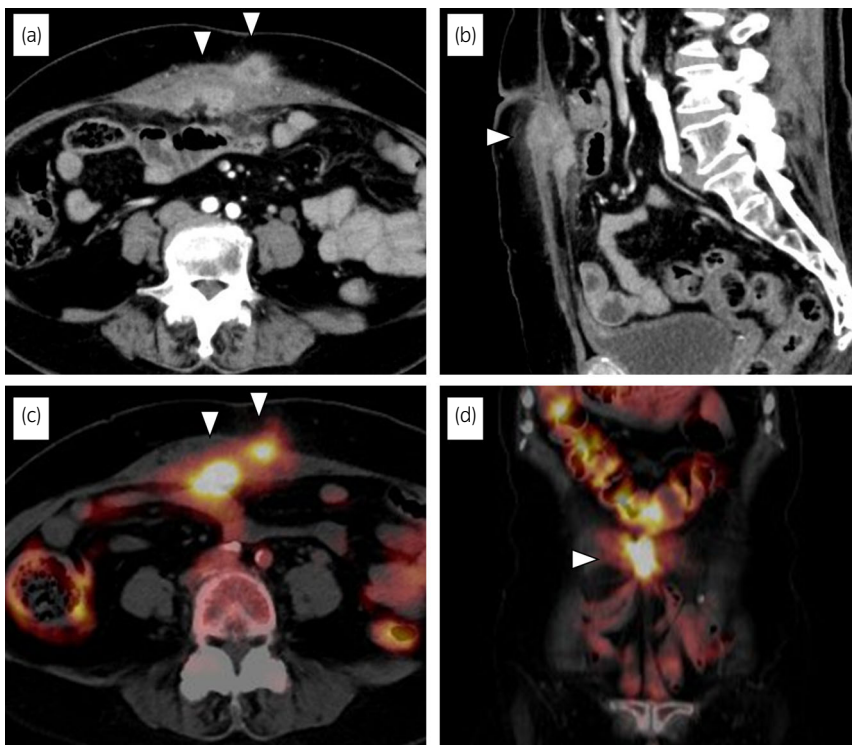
Computed tomography (CT) images of the abdominal wall mass suspected to be a urachal carcinoma. (a) Axial CT image of the abdominal wall mass (arrowheads). (b) Sagittal CT image showing an abdominal wall mass (arrowhead) connected to the urachus. (c) Axial and (d) coronal 18F-fluorodeoxyglucose positron emission tomography images of the abdominal wall mass (arrowheads).
